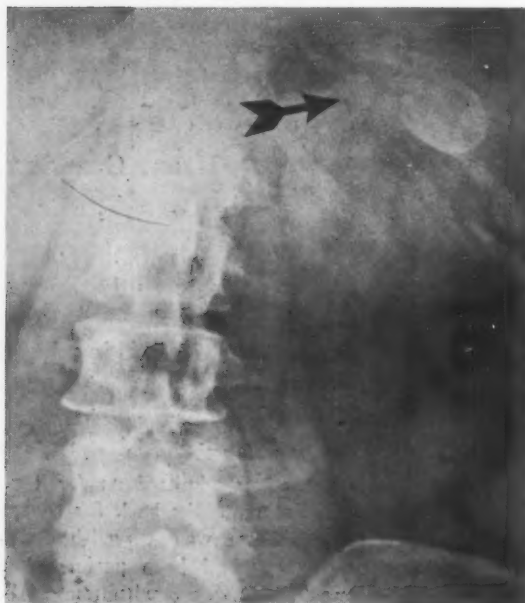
Roentgenogram of the abdomen showing the calcified ovoid shadow in the left upper abdominal quadrant suggesting the diagnosis of an aneurysm of the splenic artery. The periphery of this shadow is sharply delineated and the central portion is mottled.
